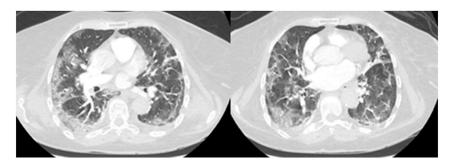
Emergency contrast chest computed tomography scans revealing peripheral bilateral patchy ground-glass opacities with consolidations. Pulmonary embolism was excluded in our lupus patient with COVID-19.
